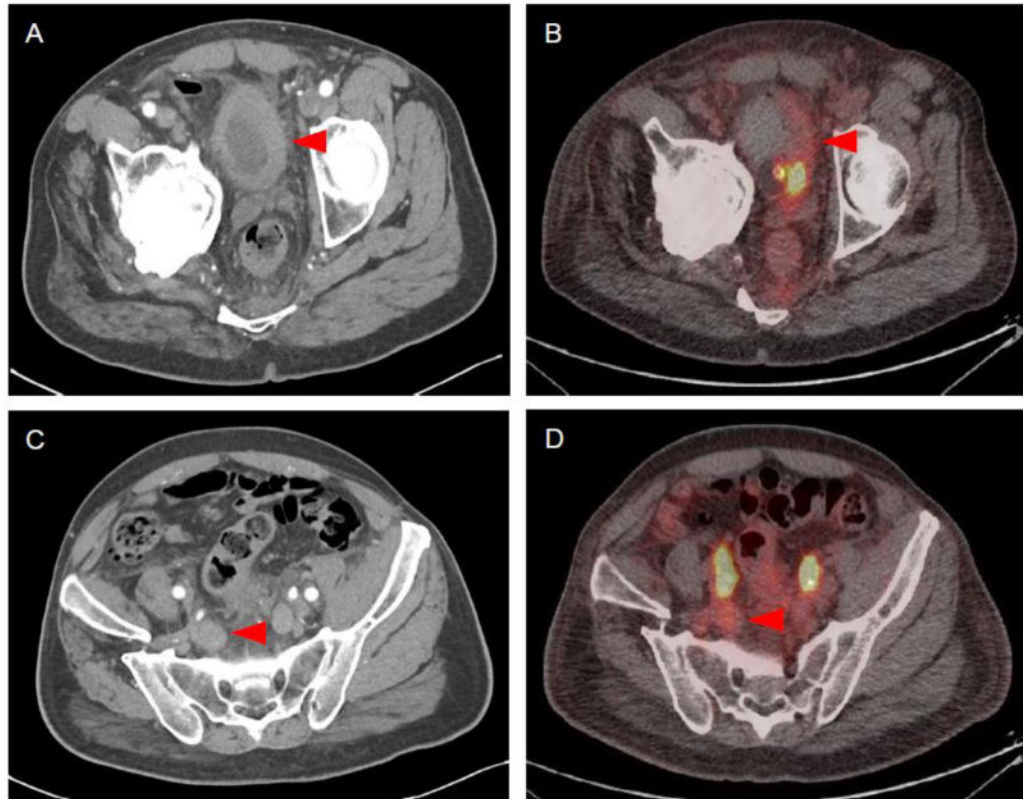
Imaging findings of Patient 2. (A) Contrast-enhanced CT demonstrated a primary tumor of the bladder. (B) This lesion had only modest radiotracer uptake on ^{18}F -DCFPyL PET/CT ($\text{SUV}_{\text{max}} = 2\text{-}2.5$). (C) Contrast-enhanced CT also demonstrated pelvic lymph node involvement. (D) This lesion was poorly localized on ^{18}F -DCFPyL PET/CT ($\text{SUV}_{\text{max}} = 2.0\text{-}2.5$).
